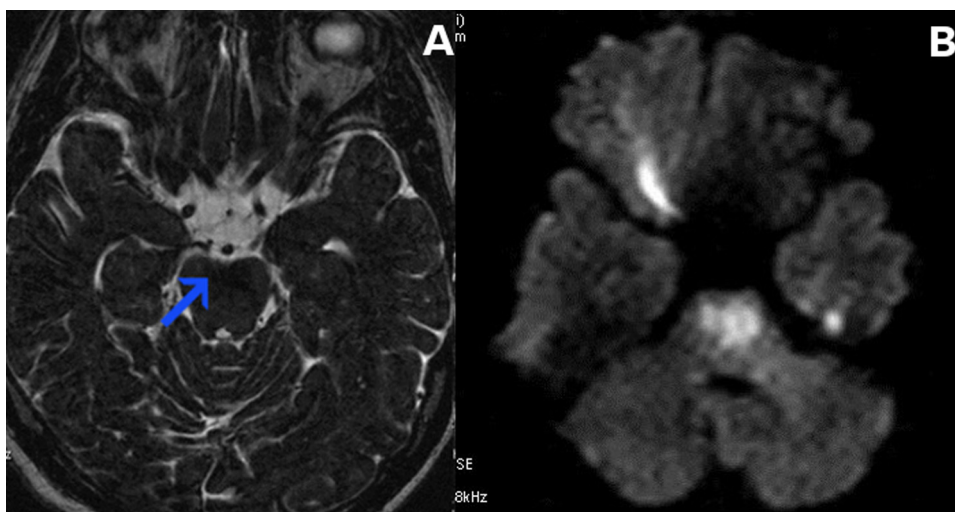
T2-weighted magnetic resonance imaging (T2-MRI) (A), diffusion weighted magnetic resonance imaging (DWI-MRI) (B). Image shows ischemic of the brainstem.
